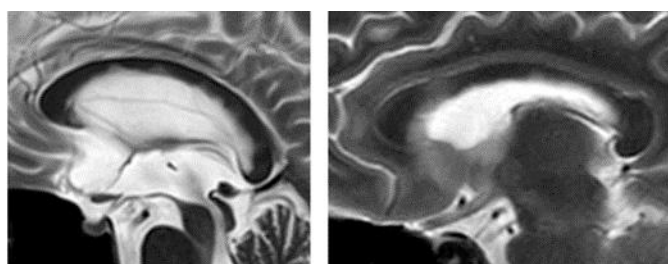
T1W, T2W and FLAIR MRI show morphology of the lesions; [1] Dawson fingers, [2] ovoid, [3] Dawson finger-like lesions (in NMOSD), [4] subcortical-U fiber, [5] tumefactive (>2cm), [6] punctate, [7] peri-ependymal (linear), [8] periependymal-dot, [9] bridging corpus callosum and [10] T1 black holes.
